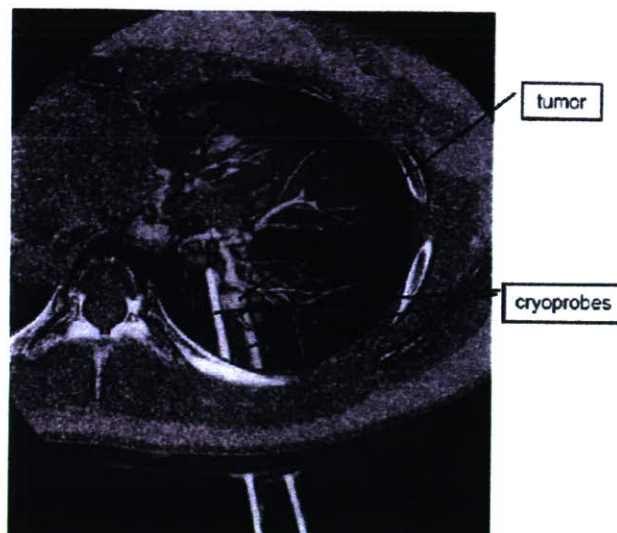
Cryoprobe can approach to the hilar lesions. A case with 6 peripheral and 1 central metastases: 6 peripheral metastases had been resected surgically. A centrally located tumor is shown in a 3-dimensional computed tomographic image. Two cryoprobes are inserted into the lung. Because the tumor was located close to a large vessel, 2 probes are inserted almost parallel, like chopsticks, so as to encase the tumor. This avoids vessel and airway damage, and preserves pulmonary function.
